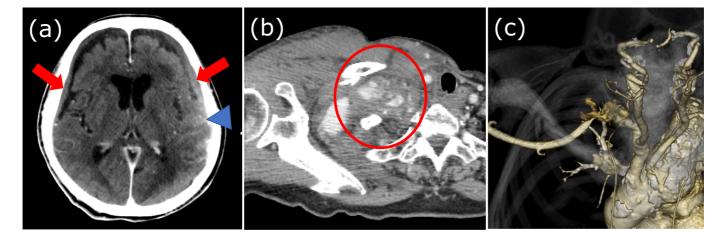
Whole-body CT at the initial arrival. (a) Head CT shows traumatic subdural hemorrhage (arrow head) and bilateral acute subdural hematomas (arrow). Neck-pelvis contrast-enhanced CT reveals hematoma around the same area as the right clavicle fracture (Robinson classification type 2B2). (b, c) Contrast medium extravasation from the vertebral artery is seen in the arterial phase (circle).
